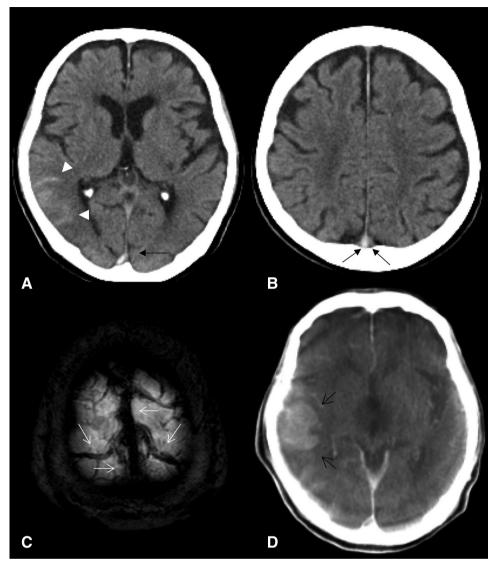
(A and B) Initial CT shows L SAH in the right temporal lobe (white arrowheads) and dense clot sign in the SSS (black closed arrow). (C) MRI (T2*WI) reveals susceptibility vessel sign in the SSS and bilateral cortical veins (white open arrows). (D) Cone-beam CT just before angiography demonstrates subcortical hematoma in the right temporal lobe in addition to local SAH (black open arrows). L SAH: local subarachnoid hemorrhage; SSS: superior sagittal sinus
